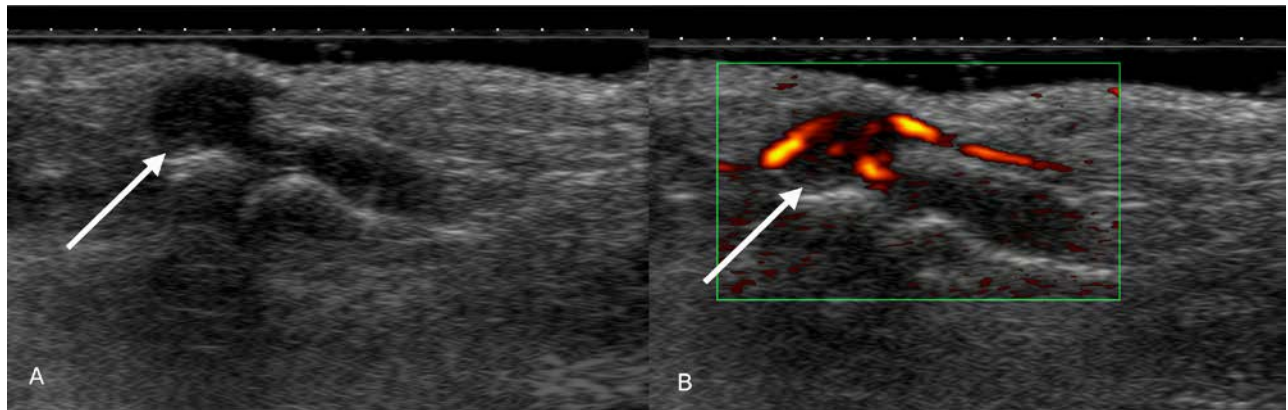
Ultrasound of the same lesion in the left index finger demonstrates localized extra-articular TSGCT adjacent to the flexor digitorum tendon sheath at the level of the proximal interphalangeal joint (arrows, A and B). The lesion appears as a solid hypoechoic nodular mass (arrow, A) with marked intralesional vascularity on colour Doppler imaging (arrow, B). These sonographic features are suspicious for localized TSGCT and explain the recommendation for complementary MRI for further characterization and assessment of intra-articular extension.
